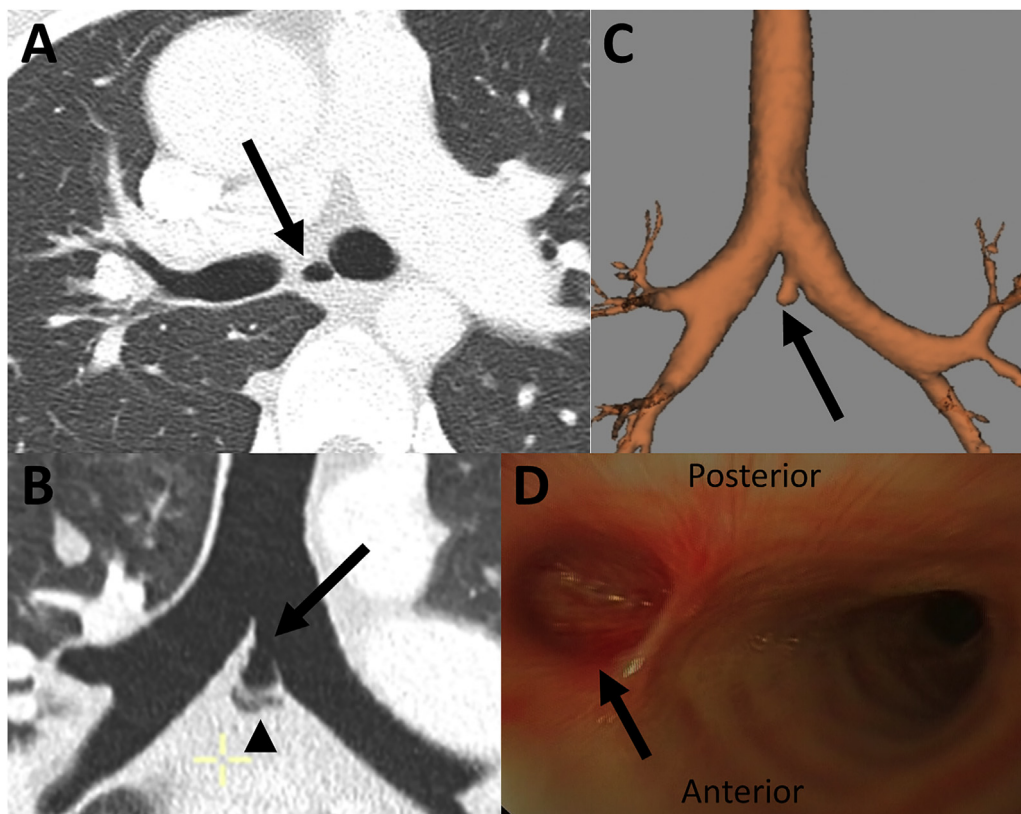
A 20-year-old man with left-sided accessory cardiac bronchus. CT images in the transverse (A) and frontal (B) plane show an accessory cardiac bronchus (arrows) arising from the left main bronchus and ventilating some vestigial aerated parenchyma (arrowhead). (C) Three-dimensional CT image using a volume-rendering algorithm shows consistent findings. (D) Photograph shows bronchoscopic view that confirms accessory cardiac bronchus (arrow) showing normal mucosa and cartilage rings within its wall.
